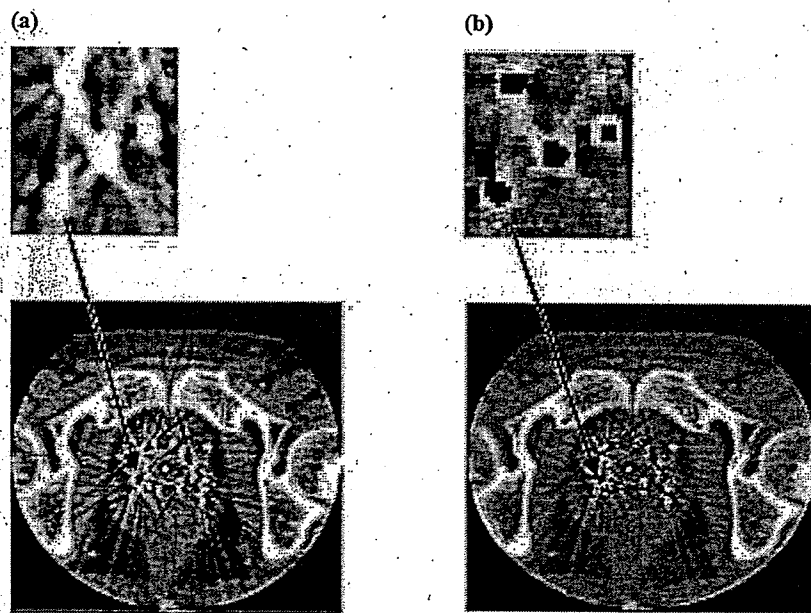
CT images of a patient who received I-125 permanent implant brachytherapy.
